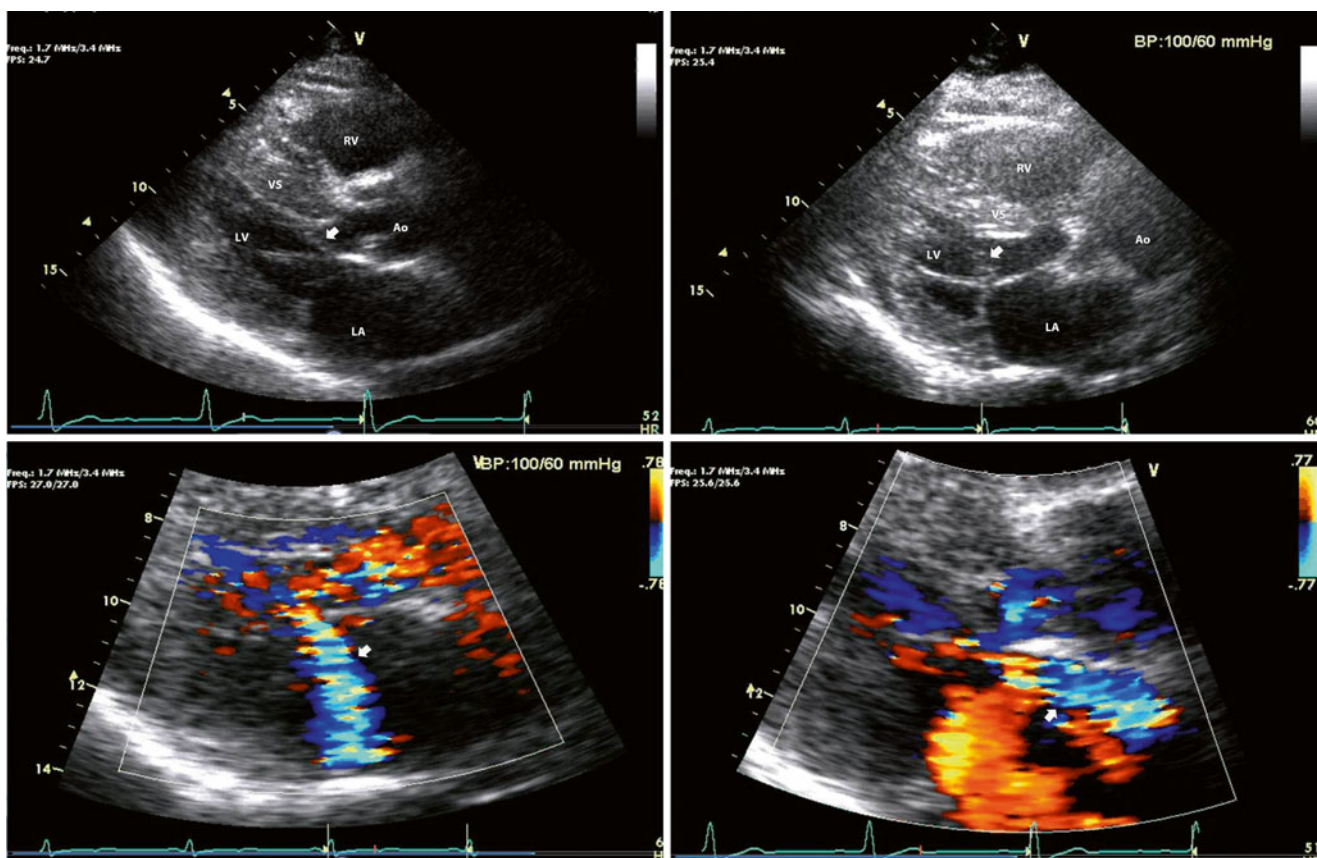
Dynamic left ventricular outflow tract (LVOT) obstruction and associated mitral regurgitation in hypertrophic cardiomyopathy (HCM). *Left*, Parasternal long-axis view from transthoracic echocardiography showing dynamic LVOT obstruction with systolic anterior motion of the mitral valve (*top*, *arrow*) and mitral regurgitation, which is characteristically posterior in direction (*bottom*, *arrow*). *Right*, Parasternal long-axis view from transthoracic echocardiography in a
